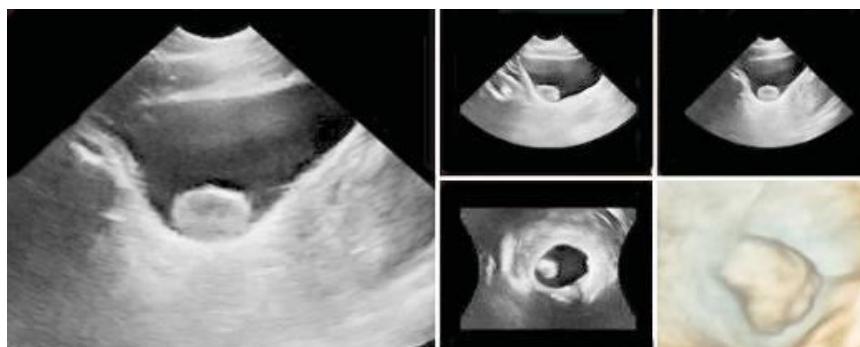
3D-sonogram of tumor bottom of the bladder
